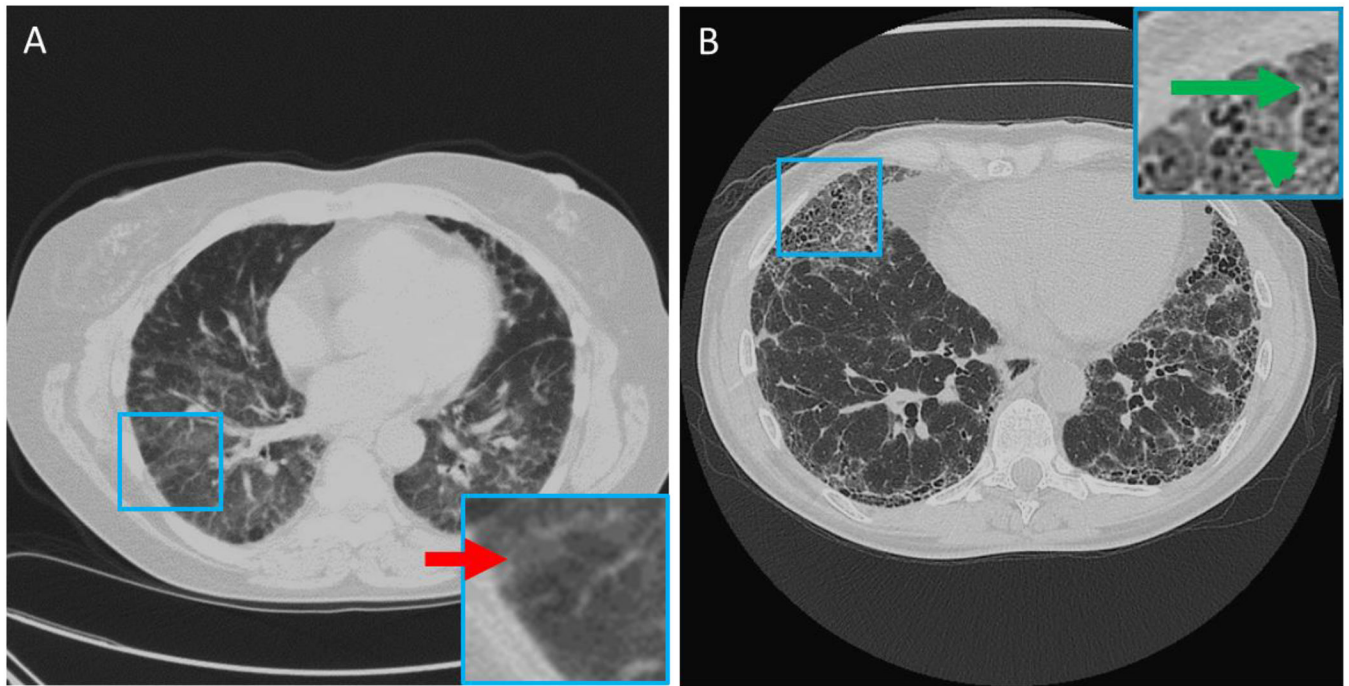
Representative high-resolution CT images of rheumatoid arthritis (RA) associated interstitial lung disease. A: Nonspecific usual interstitial pneumonia (NSIP) with ground glass opacities (red arrow in A). This patient was diagnosed with RA three years prior to the CT image. B: Usual interstitial pneumonia (UIP), characterized by reticular opacities (green long arrow) and honeycombing (green short arrow). This patient was diagnosed with RA 10 years prior to the CT image.
